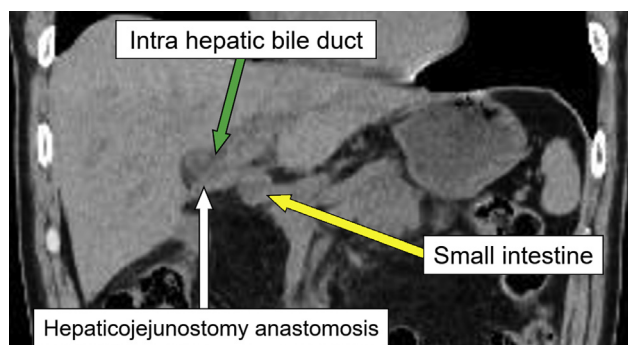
CT shows slight dilation of the intrahepatic bile duct. The cholangitis was thought to be caused by obstruction of the hepaticojejunostomy anastomosis.
